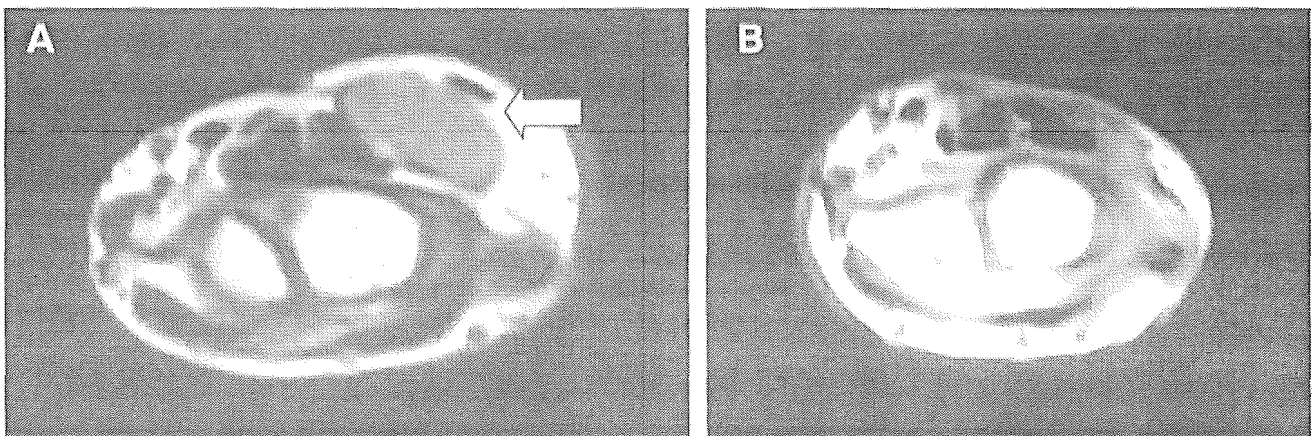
MRI findings of a patient with synovial sarcoma (Case 2) arising from the wrist. A: Coronal T1-weighted image at the wrist joint before surgery shows that the tumor is in close contact with the flexor tendons in the carpal tunnel, ulnar nerve, and blood vessels. B: Coronal T1-weighted image at 48 months after AO-PDT with AO-RDT indicates that there is no tumor recurrence.
